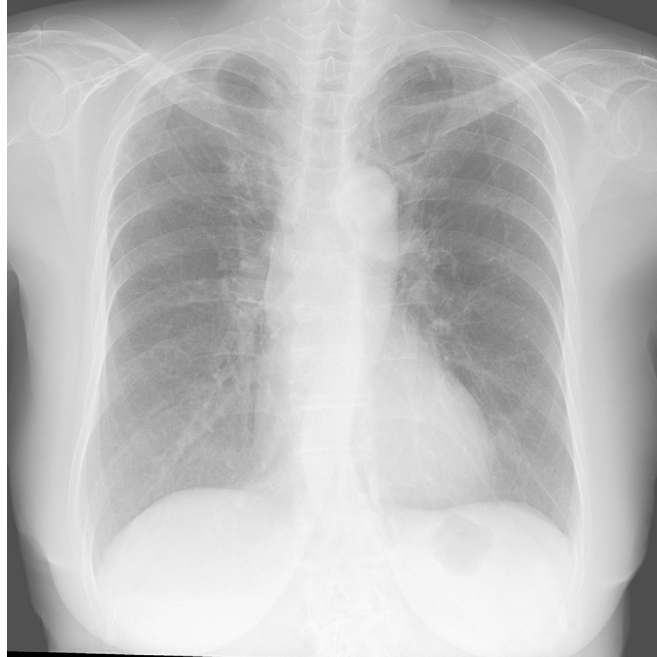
Chest X-ray at the diagnosis of ILD. It is difficult to determine the presence of ground-glass opacities.
